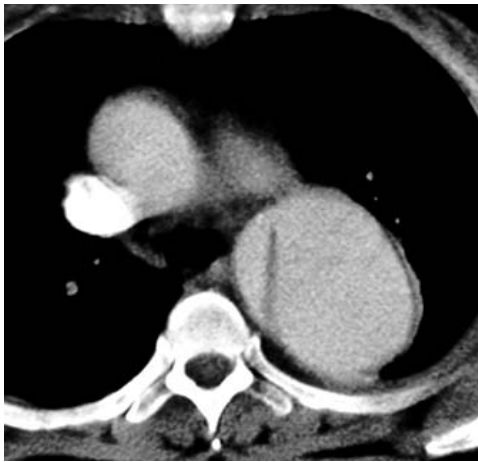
Contrast enhanced CT scan, which performed before the stent graft insertion at the descending thoracic aorta, shows DeBakey type III aortic dissection with a intimal flap (arrow) and large false lumen (white arrow).
